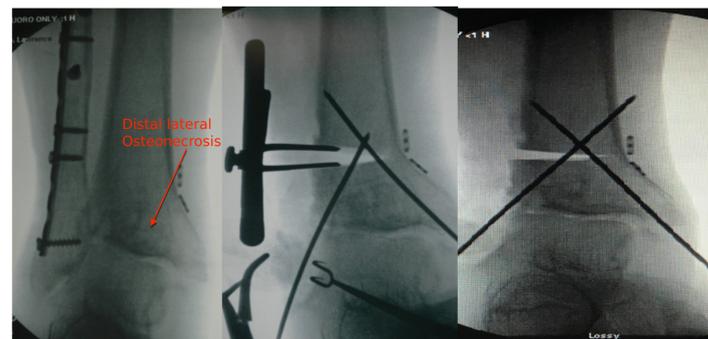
AP X-rays demonstrating pre-op valgus deformity and intra-op opening wedge tibial osteotomy.
